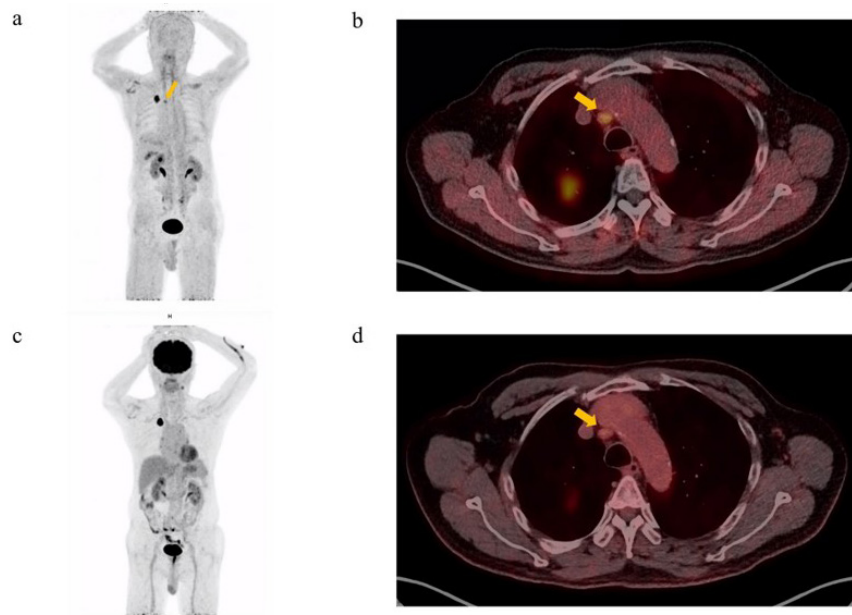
Comparison of Ga-68 FAPI PET and F-18 FDG PET images in a single patient Ga-68 FAPI PET (a-b) and F-18 FDG PET (c-d) images in a patient who were planned to receive right upper lobectomy. The right paratracheal node exhibited significant increase of uptake only in FAPI PET, which was confirmed to be the only metastatic lesion by postoperative pathologic examination.
